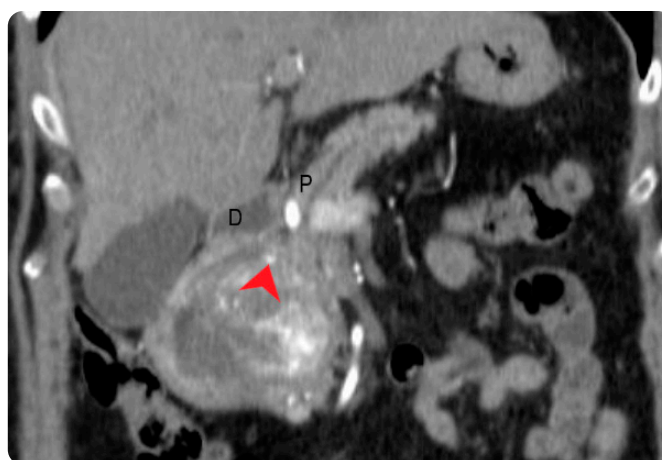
Abdominal CT, coronal: heterogeneous solid mass expanding towards the pancreaticoduodenal sulcus (red arrow). P: pancreas. D: duodenum.
